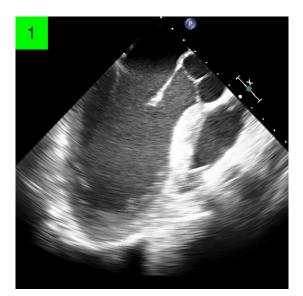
Intraoperative TEE demonstrates a dilated left ventricle prior to conversion to central ECMO. TEE was utilized for planning of cannulation site. ECMO, extracorporeal membrane oxygenation; TEE, transesophageal echocardiogram
